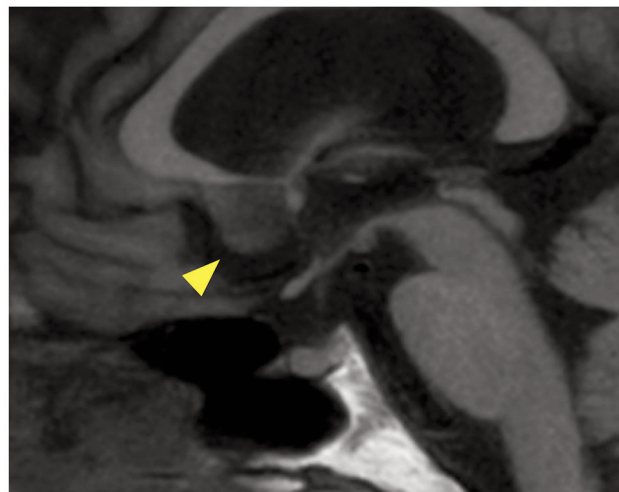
Brain magnetic resonance imaging scans showing normal size of the pituitary.
